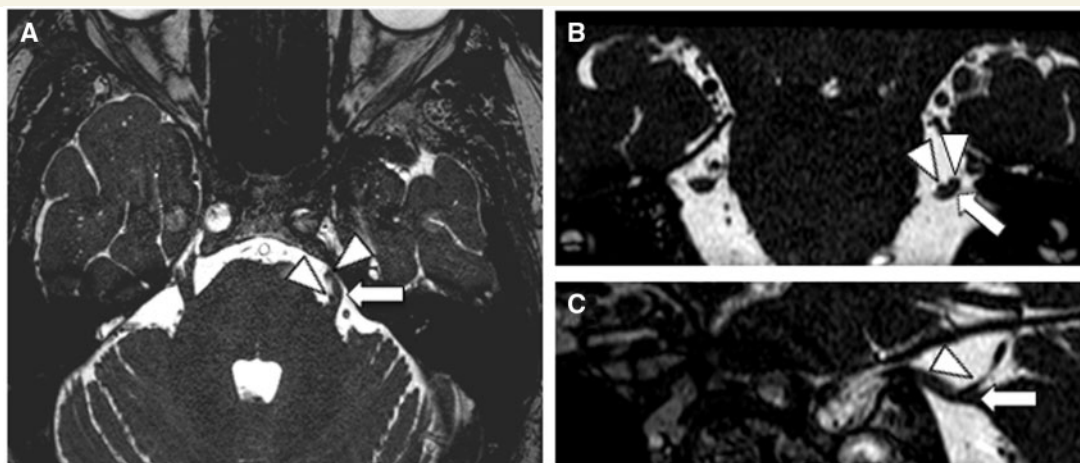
Neurovascular contact with displacement. MRI balanced fast field echo with axial (A), coronal (B) and sagittal (C) planes of the posterior fossa showing displacement of the left trigeminal nerve (arrows) caused by the left superior cerebellar artery (arrowheads) in the root entry zone. Patient suffers from left-sided trigeminal neuralgia.
